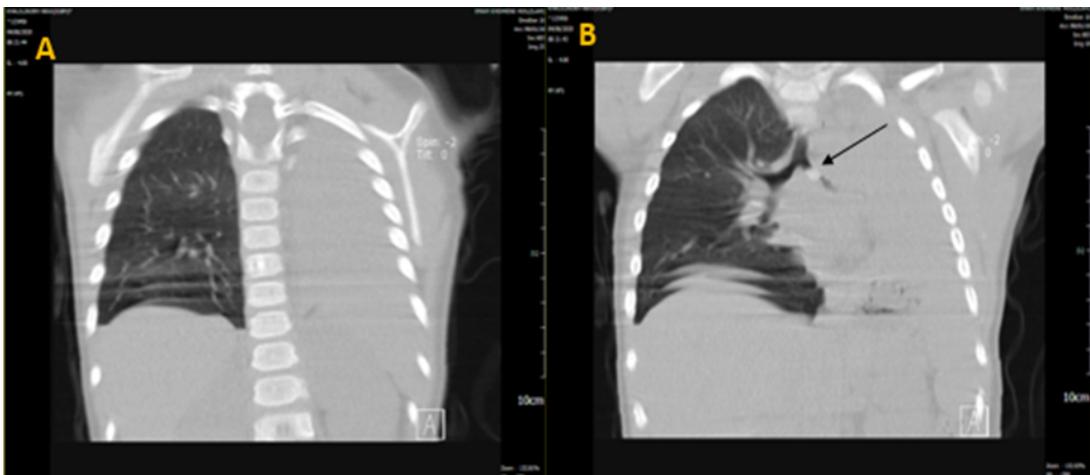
CT scan of the chest (Coronal view) showing the complete collapse in the left lung with the S sign apparatus due to complete collapse. Arrow indicates the foreign body mass in the left bronchus
